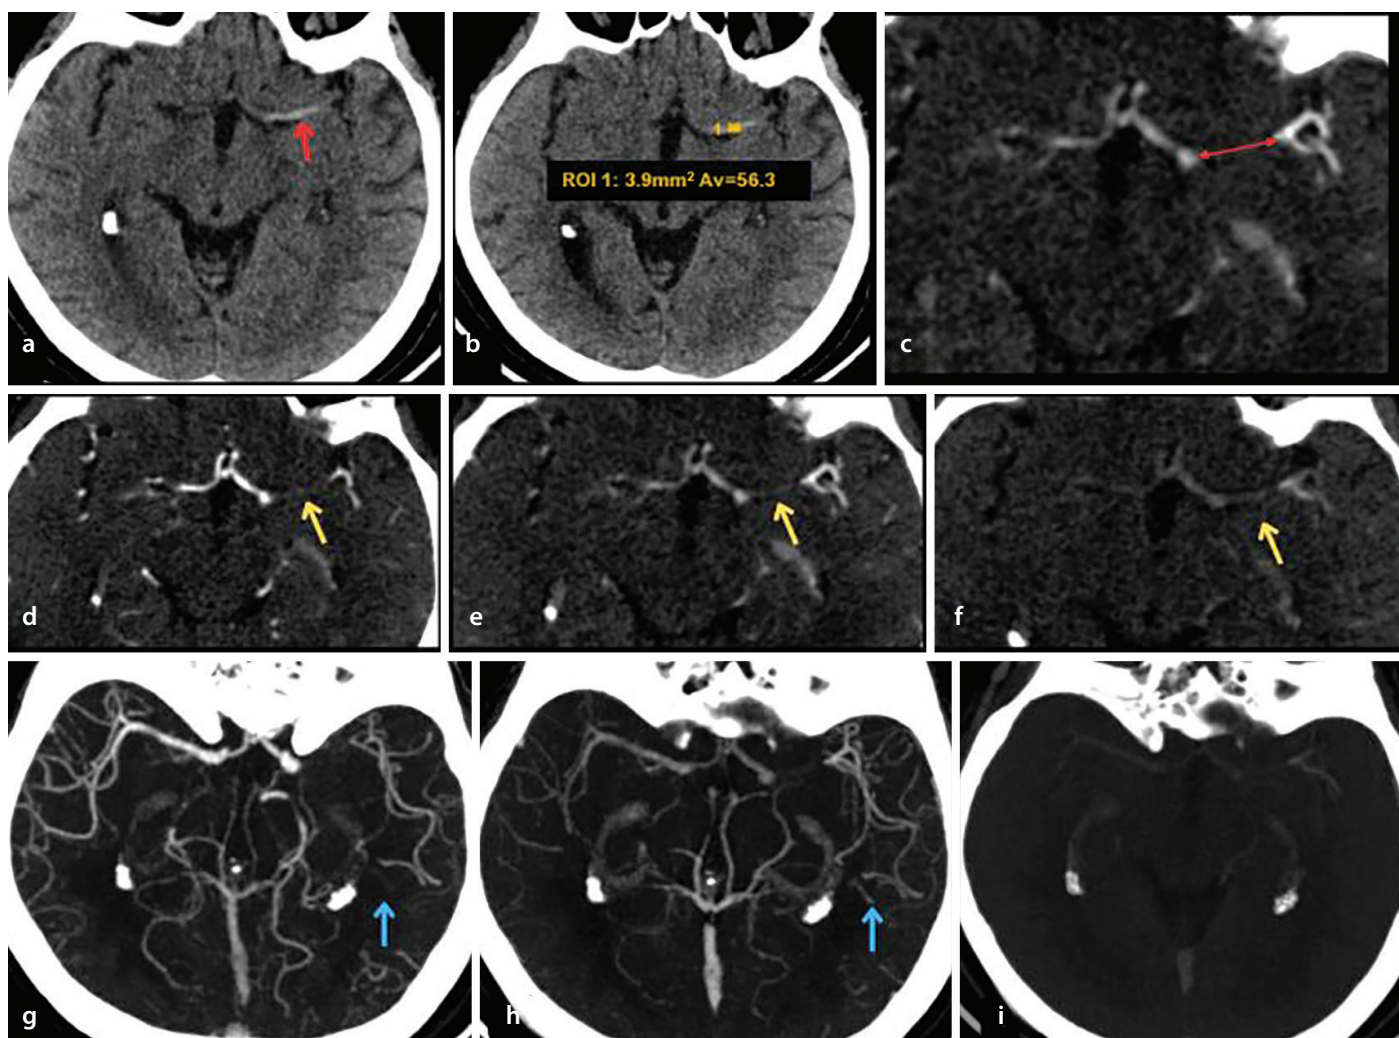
Non-contrast CT (a, b) and mCCTA images (c-i) of a 68-year-old woman with acute ischemic stroke. The time from symptom onset to mCCTA was 170 minutes. (a) NCCT shows a hyperdense MCA sign (red arrow); (b) thrombus density was calculated as 56 Hounsfield units (yellow point); (c) thrombus margins (red arrow) were best seen on the early venous phase image, and the actual thrombus length measured 15 mm (not shown). (d) Arterial phase, (e) early venous phase, and (f) late venous phase axial mCCTA images show the thrombus (yellow arrows) in the MCA M1 segment. The thrombus was located in the proximal and distal parts of the MCA M1 segment, and the clot burden score was calculated as $10 - 2 - 2 = 6$ points. MIP images of (g) arterial, (h) early venous, and (i) late venous phase mCCTA images show grade 5 collateral circulation filling (blue arrows) in the peripheral vessels distal to the thrombus. Successful recanalization was achieved with mechanical thrombectomy, and the patient had a good outcome (90-day modified Rankin scale score = 1). NCCT, non-contrast computed tomography; mCCTA, multiphase computed tomographic angiography; MIP, maximum intensity projection; CT, computed tomography; MCA, middle cerebral artery.
